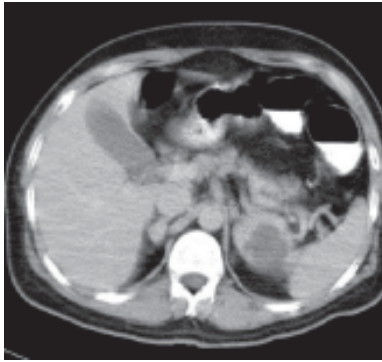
CT chest showing bilateral adrenal mass lesion
